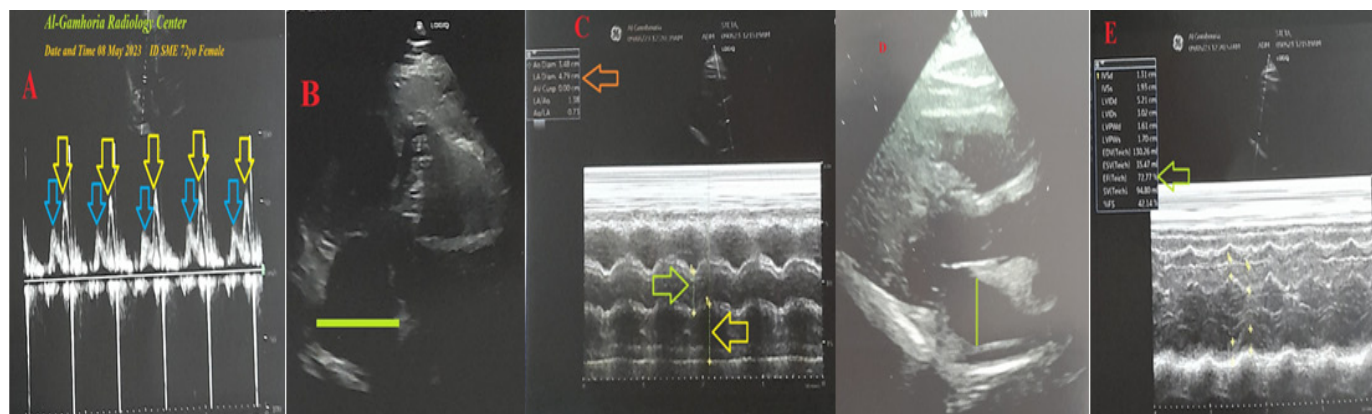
Echocardiography was done within 24 hours before the supposed surgical intervention and showed diastolic dysfunction (yellow and blue arrows), dilated left atrium in apical 4-chamber (lime rectangle), M-mode (orange and yellow arrows), and 2-D-view (lime rectangle) with EF of 72.7% (lime arrow).
